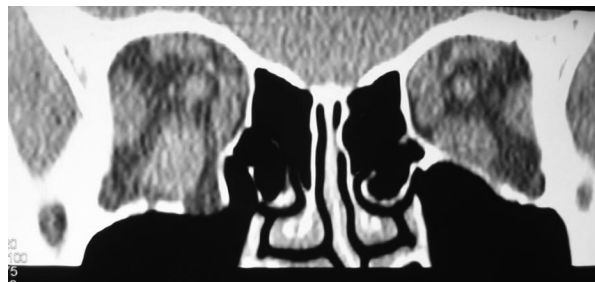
CT scan of the mid-orbit section (coronal view) shows a right floor fracture medial to inferior orbital groove.
